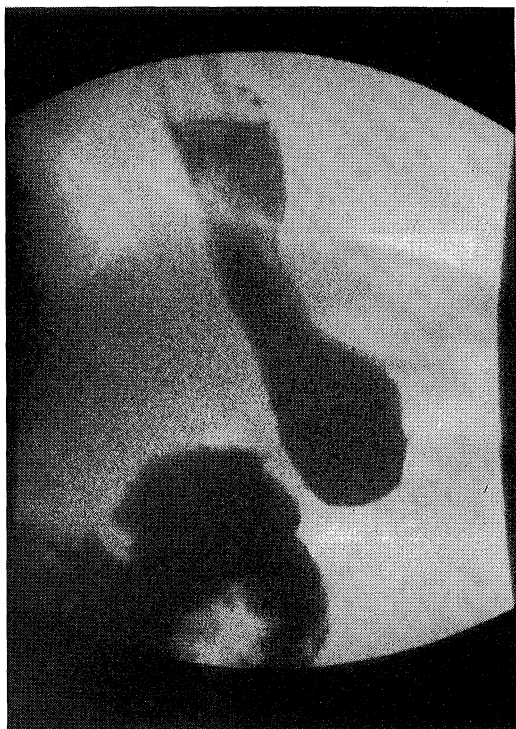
Postoperative X-ray picture (pyloric portion).
